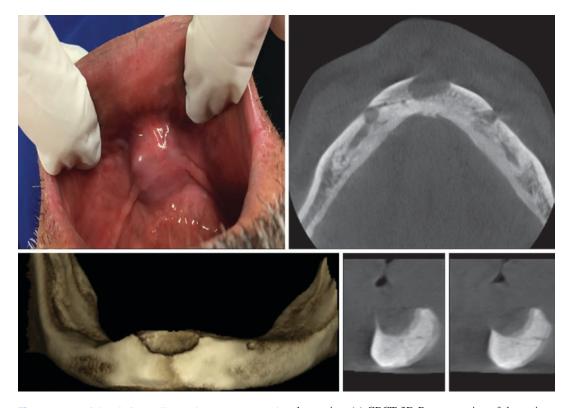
Peripheral giant cell granuloma. (a) Intraoral swelling is seen at edentuluos mandibular anterior site. (b) CBCT axial slice reveals a unilocular, well-defined non-corticated hypodense lesion with buccal cortical plate
